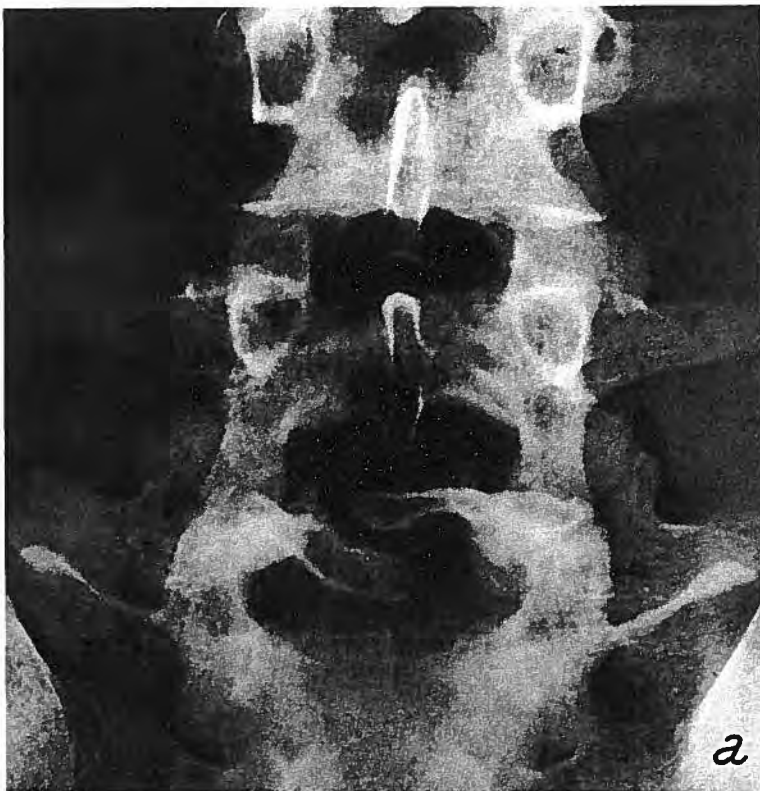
a A lateral radiograph of the lumbar spine of a man aged 45, showing Grade 2 spondylolisthesis at L5/S1, with discograms at L2/3, L3/4 and L4/5. Post-traumatic disc disruptions are shown at each level, causing severe back pain. The patient had fallen from a height of 25 feet (8 metres). b A lateral tomogram of the same patient's spine taken 9 months after an extensive multi-level posterior spinal fusion, which was planned after the discography shown in Fig. 5.8a
